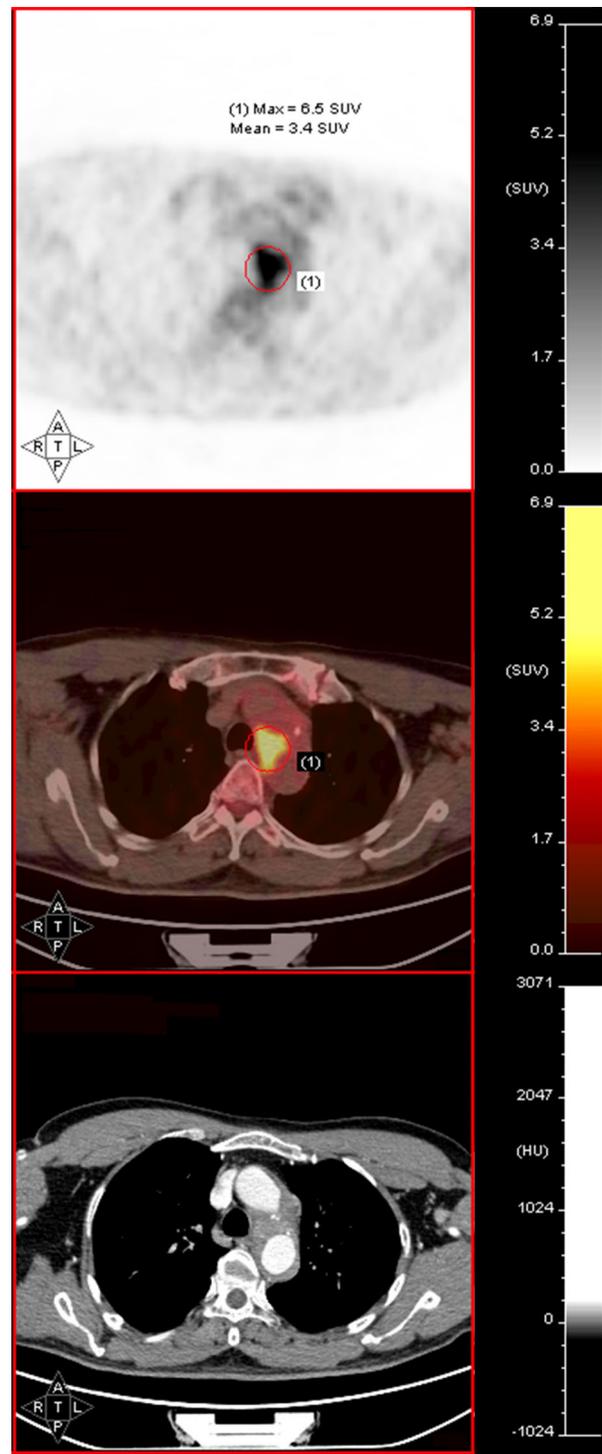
Three images represented PET, PET/CT, and contrast-enhanced CT, respectively (from top to bottom). A circular ROI was placed over the positive site and the maximum SUV were measured.
